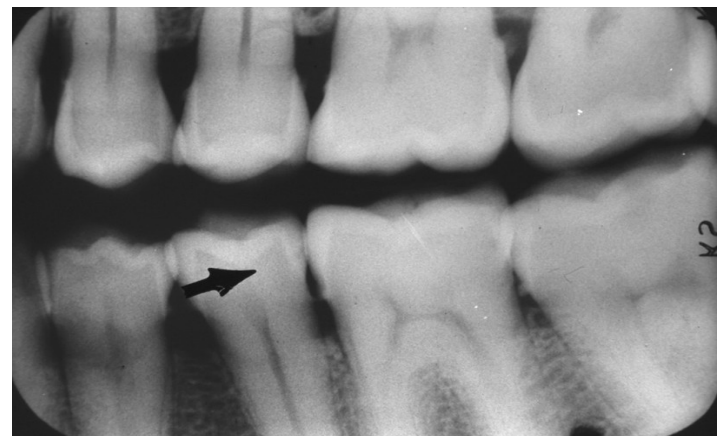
This left bitewing radiographic image of an adult shows evidence of proximal caries on the distal surface of the mandibular second premolar. In this image the early carious lesion appears confined to the enamel.
